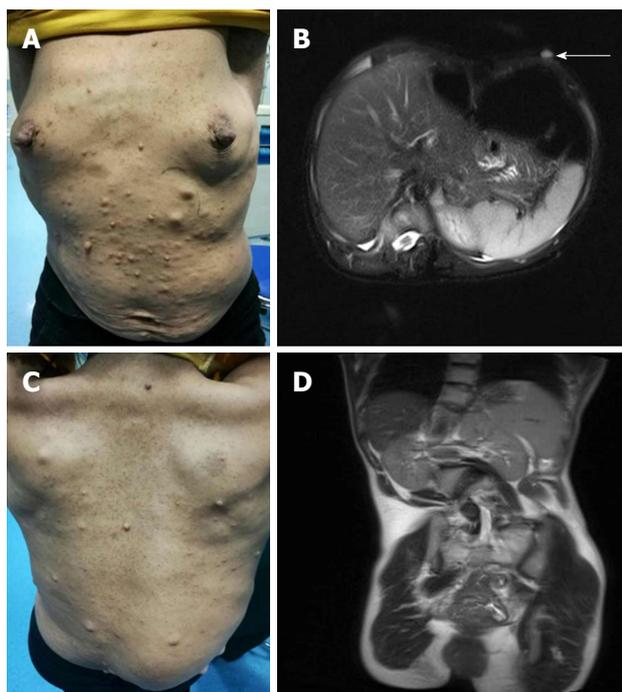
Patient skin changes and spinal deformities. A: Patient presented with multiple subcutaneous nodules and café au lait spots; B: MRI detected multiple nodules with uniform densities and clear boundaries that were visible on the chest and abdomen (white arrow); C: Scoliosis was noted at the spinal column; D: MRI identified scoliosis and thoracic deformity. MRI: Magnetic resonance imaging.
